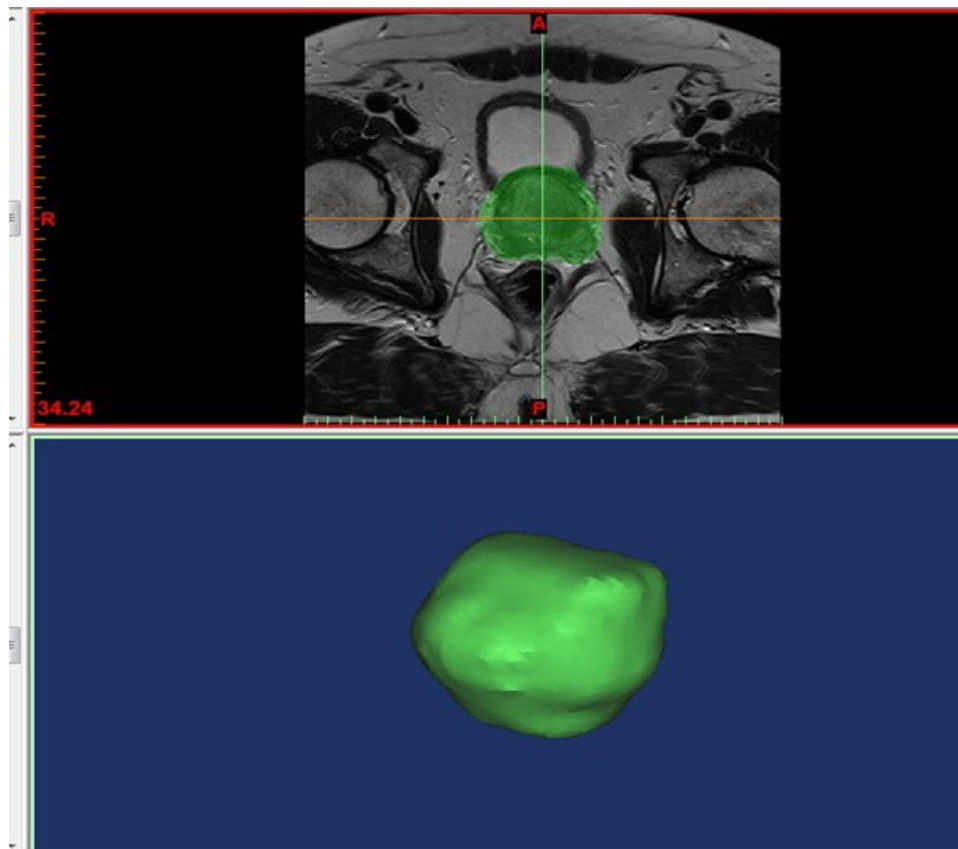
Segmentation of the prostate (green area) of MR imaging
